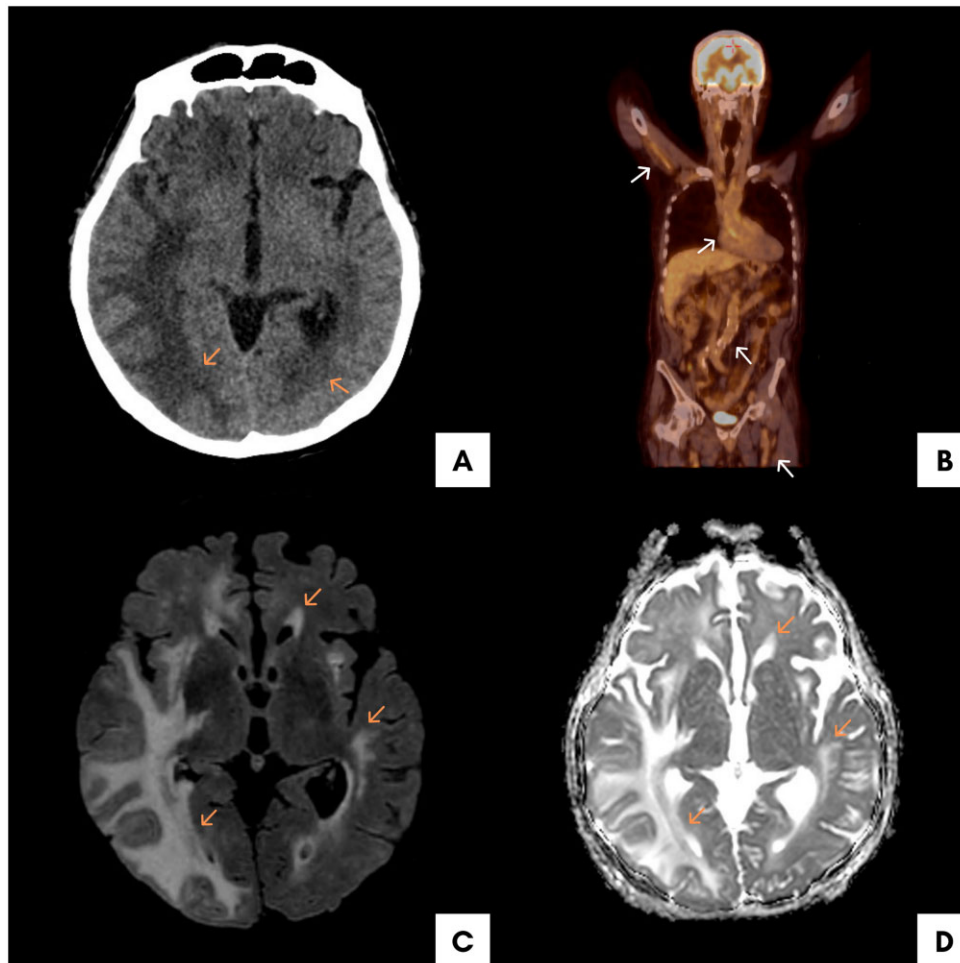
Neuroimaging of posterior reversible encephalopathy syndrome in the context of a GCA. (A) Non-contrast-enhanced head CT scans of the head showing hypodensity of the right cerebral hemisphere and left temporal-polar region. (B) 18-Fluorodeoxyglucose PET/CT showing an increased glucose uptake of the walls of large vessels. Contrast-enhanced MRI of the vasogenic oedema, revealed in the same areas as (A), as (C) hyperintensity in fluid-attenuated inversion recovery images and (D) increased apparent diffusion coefficient map values in diffusion-weighted imaging sequences
